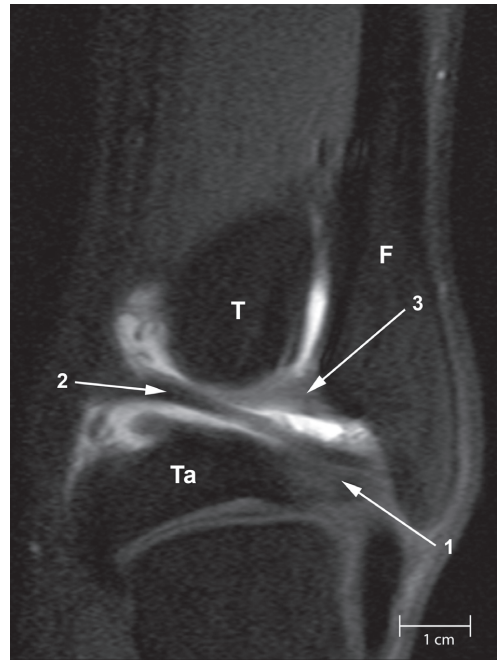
MR-artrograph: coronal T1-weighted image with fat suppression and with intra-articular contrast in the tibiotalar joint (male, 23 years). The fibula (F), the posterior malleolus of the tibia (T) and the posterior body of the talus (Ta) are visible. The posterior talofibular ligament (TFP) (1) runs more or less horizontally from the fibular fossa to the posterior process of the talus. Just above the origin of the TFP in the fibular fossa, the intermalleolar ligament originates (2), extending medially and fusing with the transverse ligament (3) at the medial aspect of the posterior ridge of the distal tibia. The transverse ligament runs between the posteromedial fibula, just above the fibular fossa, and the posterior ridge of the distal tibia. F, fibula; T, tibia; Ta, talus.
